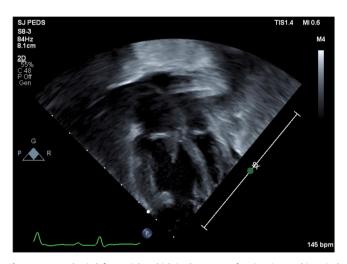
Hypoplastic left ventricle, which is almost apex forming, is noted in apical four-chamber view. The right ventricle appears moderately dilated and moderately hypertrophied. The mitral valve appears moderately hypoplastic.
